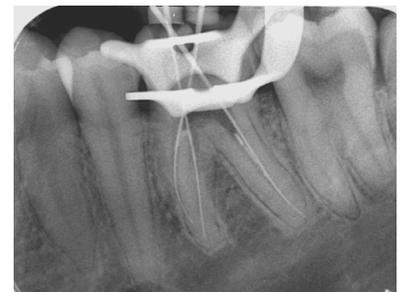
Diagnostic radiograph showing a file that is short in the mesiolingual canal
